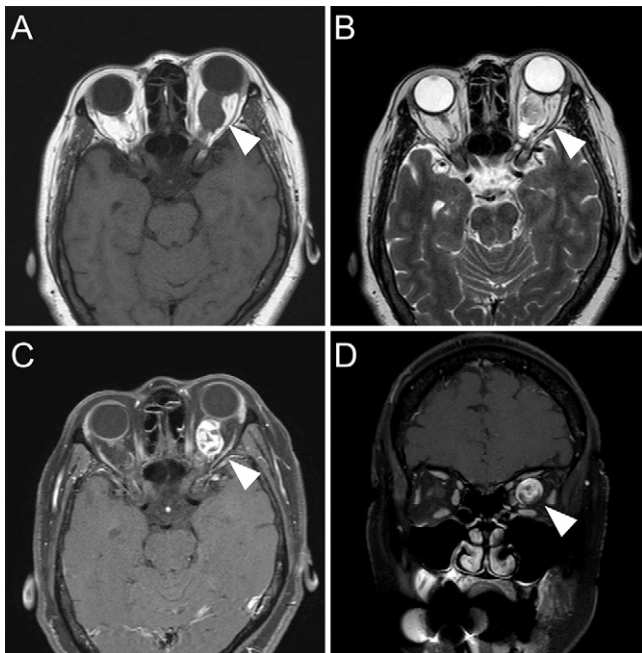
Axial T1- (A) and T2-weighted (B) MRI show a well-defined mass lesion in the left orbit (arrowheads). The tumor was heterogeneously enhanced in contrast-enhanced T1-weighted MRI with fat saturation (C and D, arrowheads).
